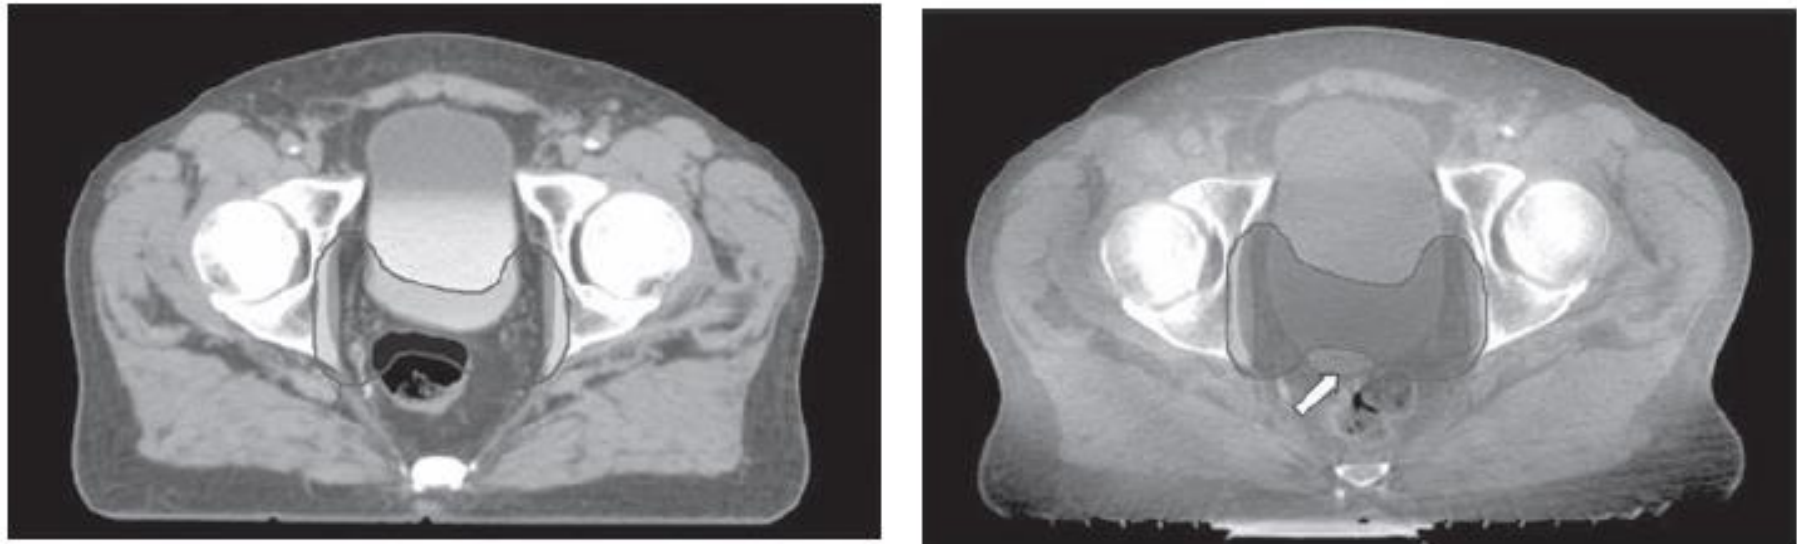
CBCT of a patient undergoing radiotherapy following radical prostatectomy. Panel (a) shows the initial planning scan with the PTV displayed. Panel (b) shows a change in rectal volume resulting in the treated volume shifting outside the planning PTV (white arrow). CBCT, cone beam computed tomography; PVT, planning target volume.
